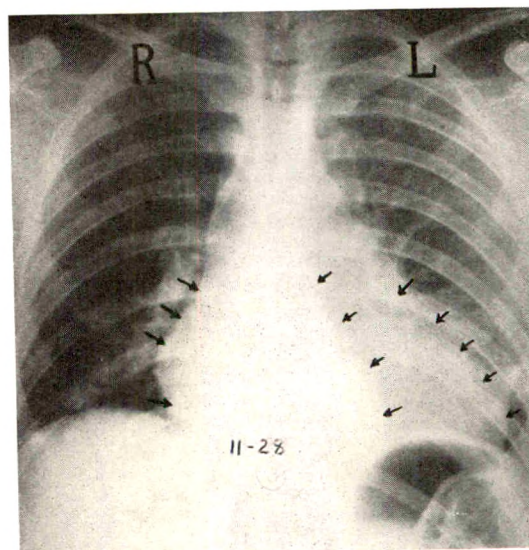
Roentgenogram of Case 1 showing left posterior mediastinal empyema with displacement of heart to right. Inner row of arrows on left side shows left heart border and outer row of arrows shows lateral border of the empyema. Note increased density where empyema overlaps cardiac shadow. Pus was obtained on posterior thoracentesis on the left side.
